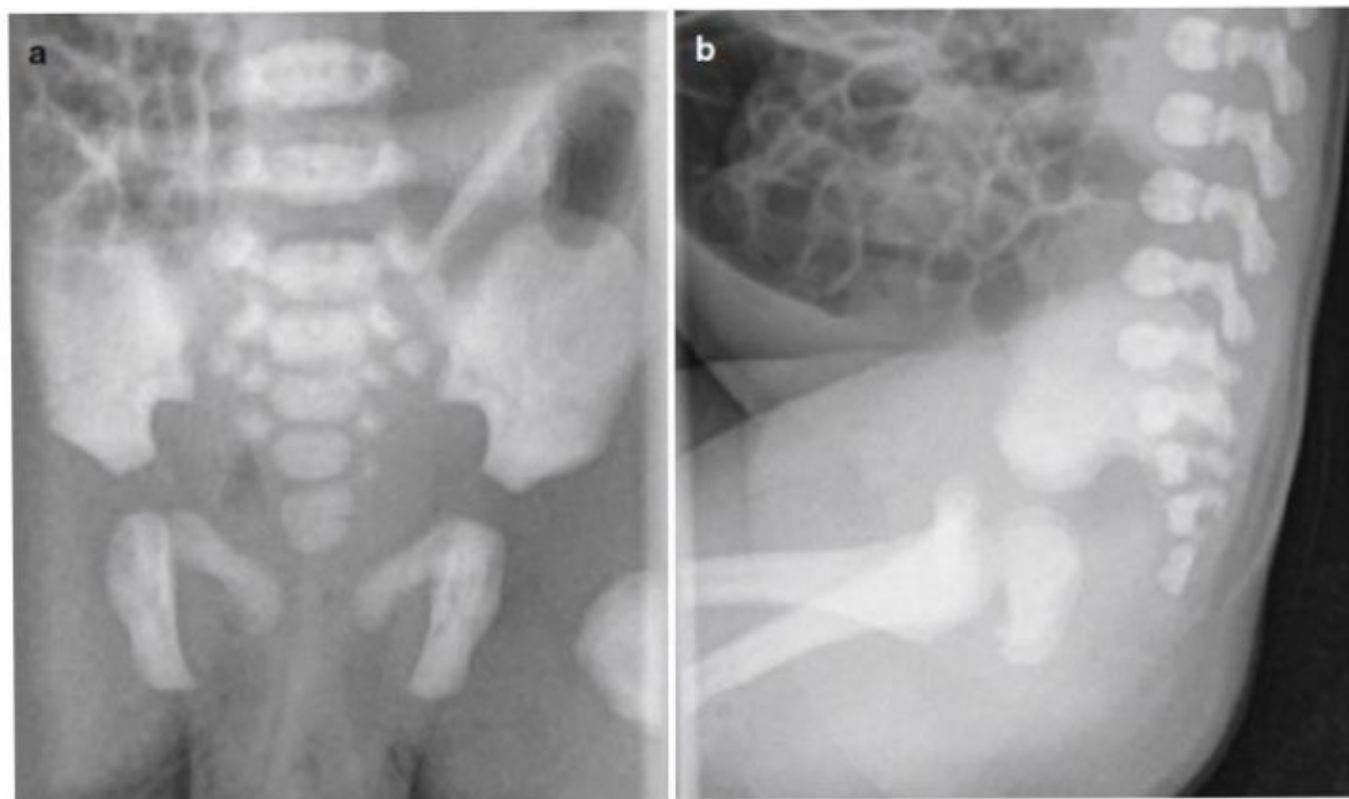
X-ray films of a normal sacrum in a baby with an anorectal malformation. (a) AP view. (b) Lateral view
